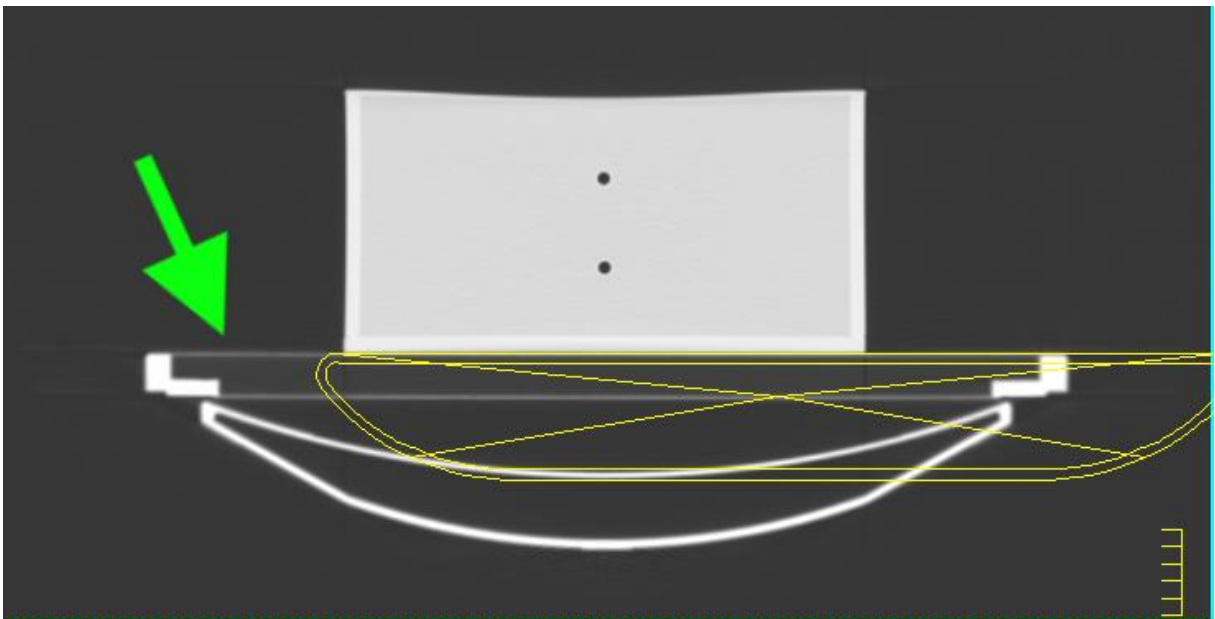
Showing how the CT scanner couch is not covered by the treatment couch structure
